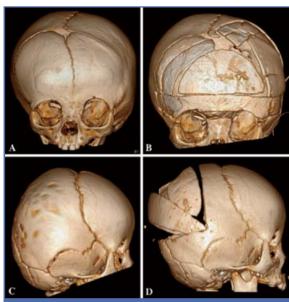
Skull reconstruction for craniosynostosis with bioabsorbable plates and pins. A and B: Pre-operative (A) and post-operative (B) 3D CT images of a child with left coronal suture synostosis. C and D: Pre-operative (C) and post-operative (D) 3D CT images of a child with partial sagittal and bi-lambdoid synostosis.
